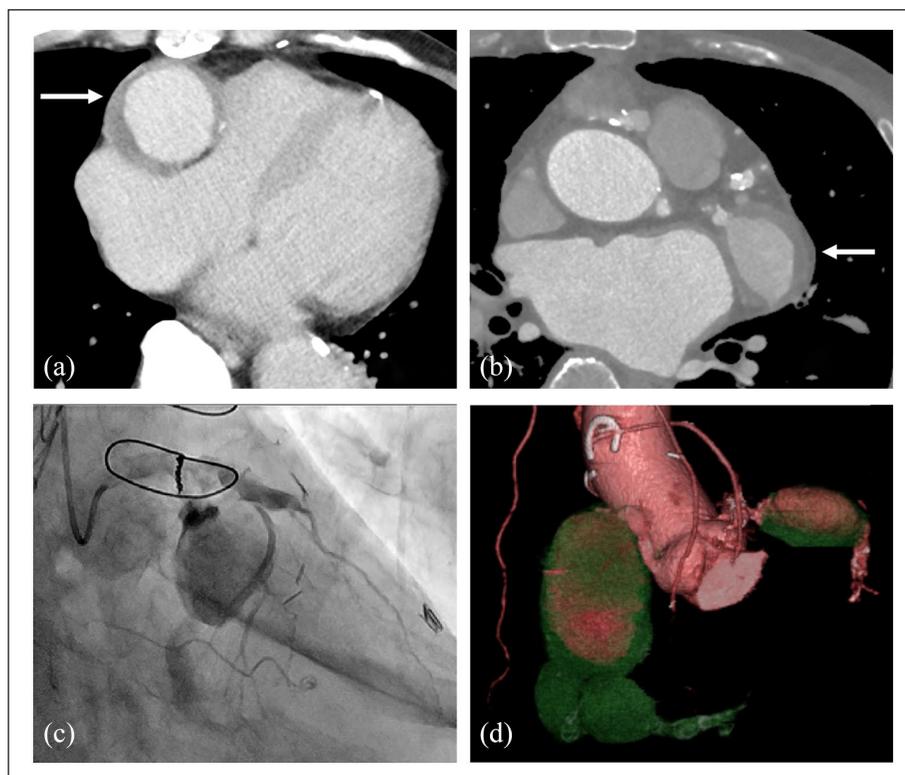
The situation immediately before the second surgery. An enhanced computed tomographic image (a) showing the CAAs (45 mm in diameter) in the right coronary artery and (b) the CAA (30 mm in diameter) in the left circumflex artery (arrows). Note that the CAA compresses the right ventricle. Coronary angiography also reveals the (c) CAA in the left circumflex artery. (d) Three-dimensionally reconstructed computed tomographic images show the CAAs.
